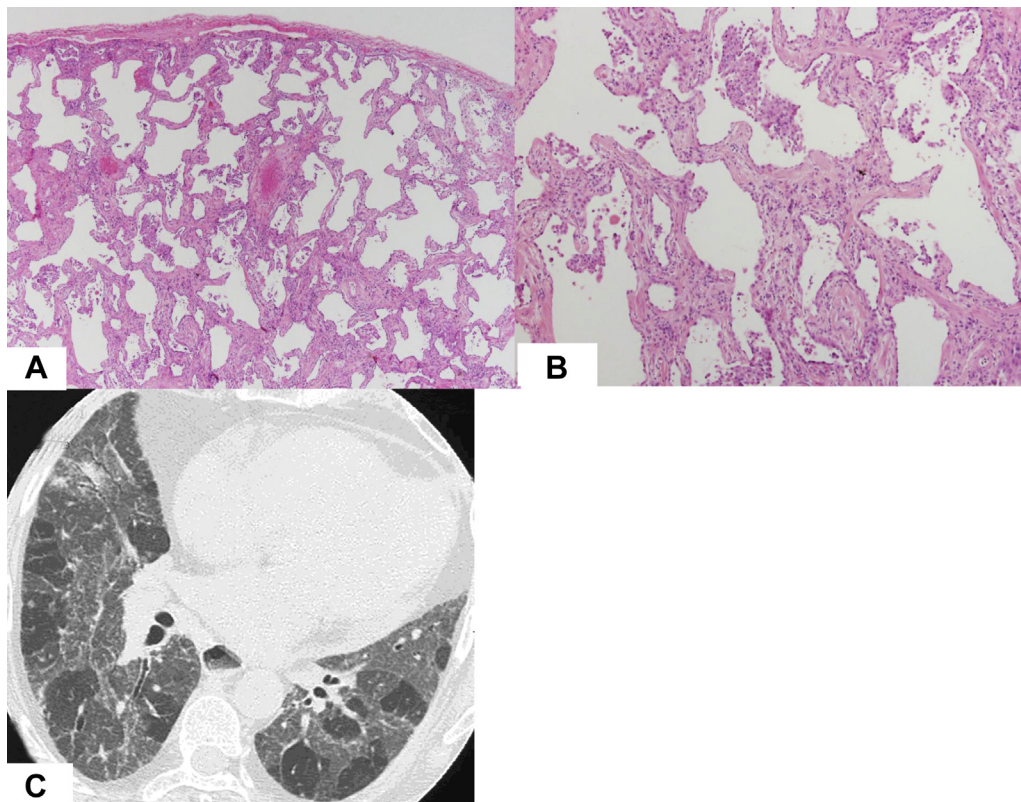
Indeterminate for fibrotic hypersensitivity pneumonitis (HP) by surgical lung biopsy but typical fibrotic HP by CT imaging.* A, A fibrosing pattern of nonspecific interstitial pneumonia was seen in this biopsy with diffuse involvement of the alveolar parenchyma lacking any bronchiolocentric distribution. No granulomas or honeycombing are seen. B, The alveolar walls show uniform thickening by fibrosis with mild chronic inflammation. The CT scan showed the typical HP pattern. Typical HP by CT imaging. C, This CT scan is from the patient whose biopsy in panels A and B showed a fibrosing pattern of nonspecific interstitial pneumonia. It shows the three-density sign (predominant ground-glass attenuation with areas of normal attenuation and mosaic attenuation) with mild reticulation and traction bronchiectasis. This combination of findings provides strong support for the diagnosis of HP rather than idiopathic nonspecific interstitial pneumonia.
